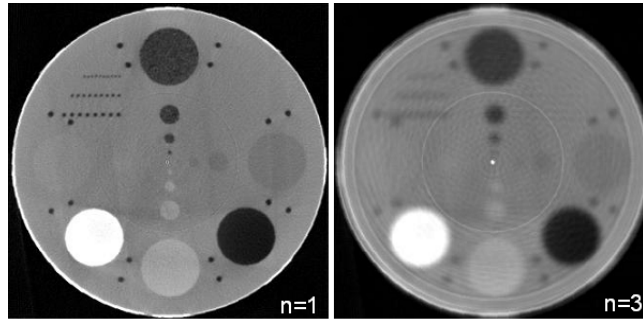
Reconstructions of rebinned CBCT projections
